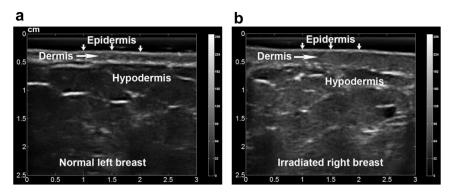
Ultrasound B-mode images of an (a) untreated (normal) breast and (b) irradiated breast. The two layers of the skin, epidermis and dermis, can be seen in both images. Radiation-induced skin injury is evidenced by the skin thickening and segmented dermis-hypodermis interface on the B-mode images.
